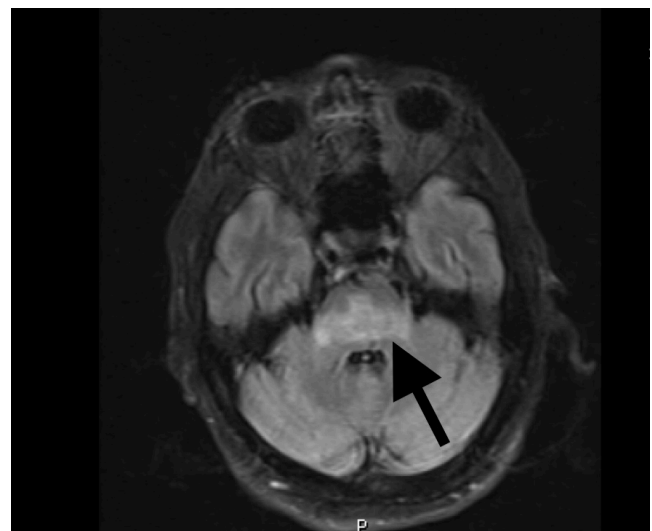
Hyperintense lesions in FLAIR MRI (white arrow)
